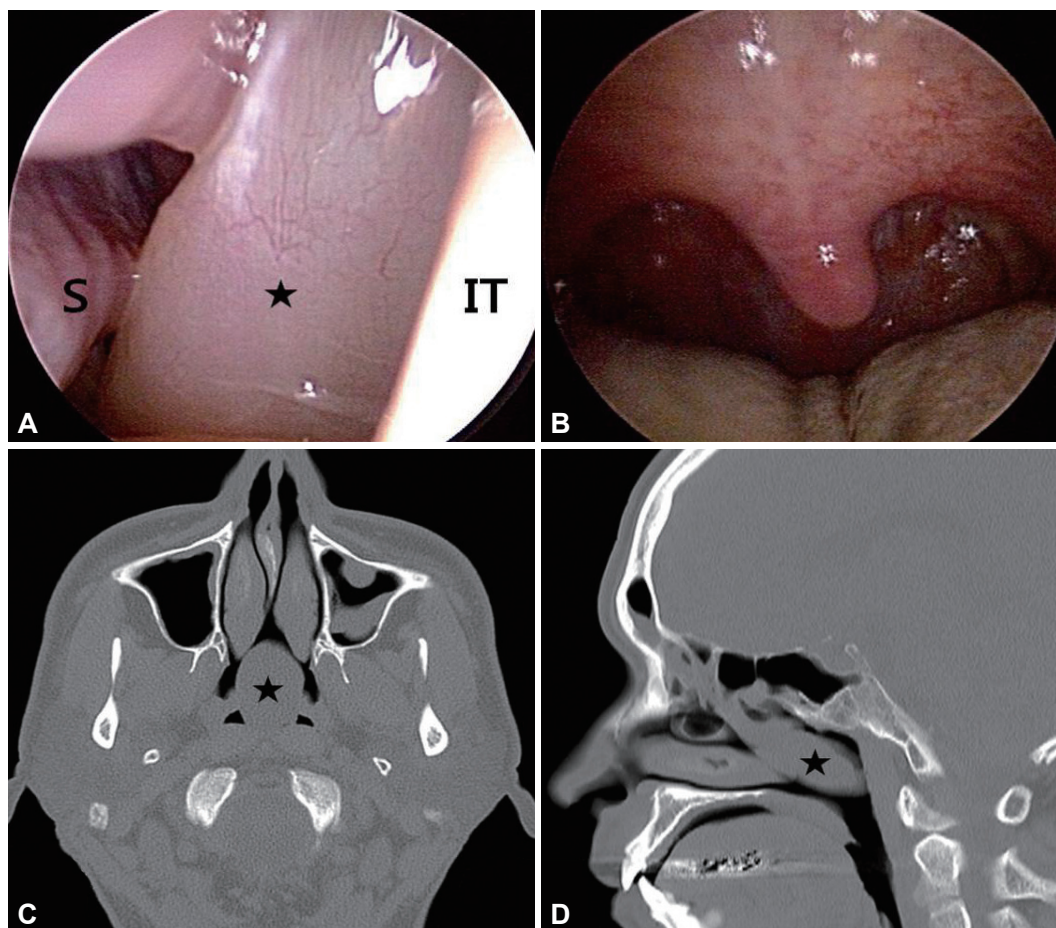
Nasal mass presenting as moderate obstructive sleep apnea syndrome (Case 3). Left posterior nasal (A) and oral (B) endoscopic findings and axial (C) and sagittal (D) views of computed tomography showed a large mass occupying the nasopharynx. IT: inferior turbinate, S: septum, black asterisk (★): nasal mass.
